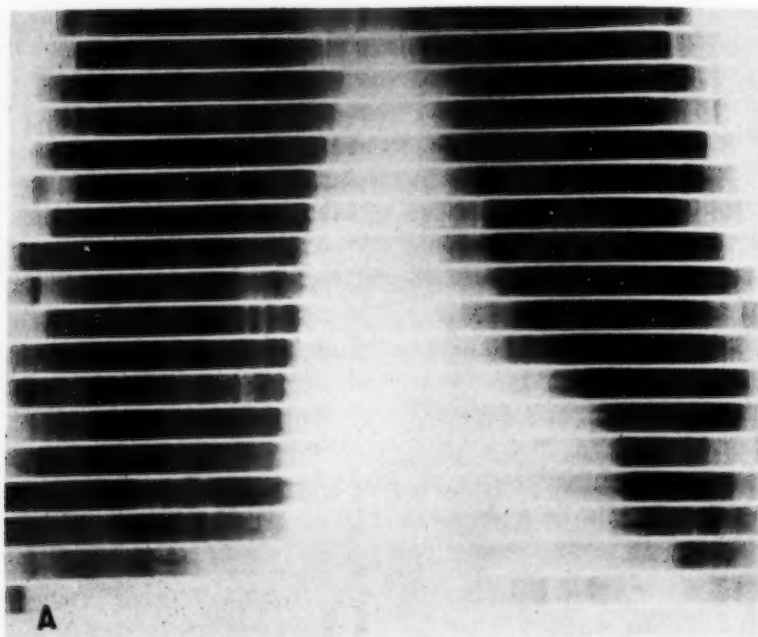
A. Cardiac roentgenkymogram of patient with myasthenia gravis. Note spike-like configuration of waves along left ventricular border.
